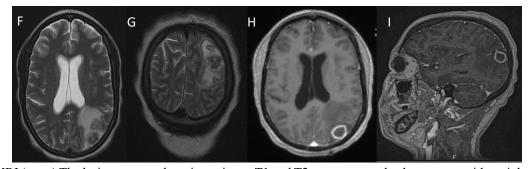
Brain MRI (cont.) The lesion presents hypointensity on T1 and T2 sequences and enhancement with peripheral contrast uptake (images H and I). F. Axial T2 Sequence; G. Coronal T2 Sequence; H Axial T1 sequence with contrast; I. Contrast-enhanced Sagittal T1 Sequence.
